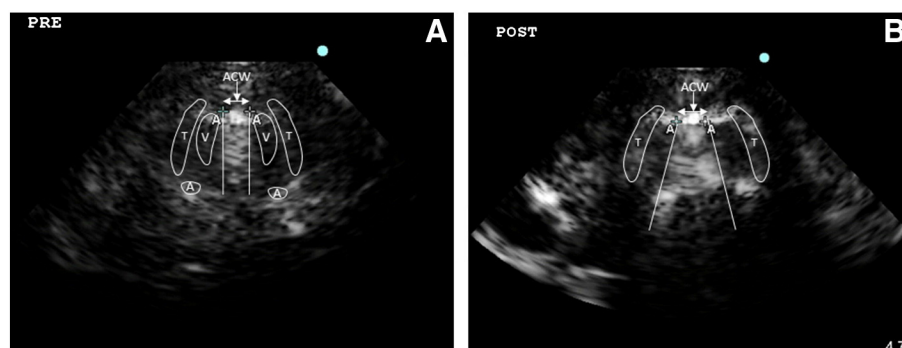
The imaging from laryngeal ultrasound demonstrates the ACW before (A) and after (B) endotracheal tube cuff deflation. After cuff deflation, the fan-shaped widening ACW obliterates surrounding structure such as vocal cords and arytenoids cartilage by acoustic shadow (T, thyroid cartilage; V, vocal cord; A, arytenoids cartilage).
